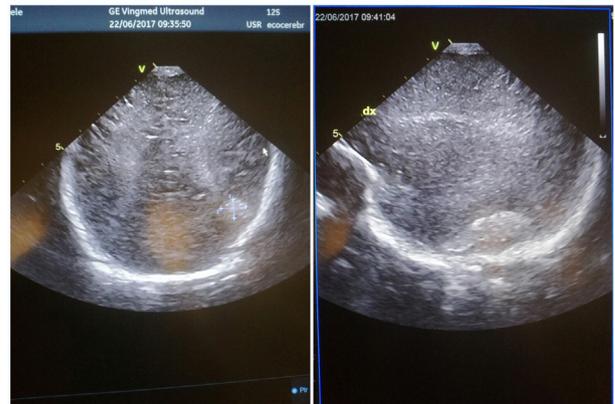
Cerebral Ultrasonography at 6 h of life: diffuse bilateral white matter hyperechogenicity and an hyperechogen area in the right parietal region ( $2,1 \times 1,4$  cm in the coronal scan and  $3,4 \times 1,1$  cm in the sagittal scan).
